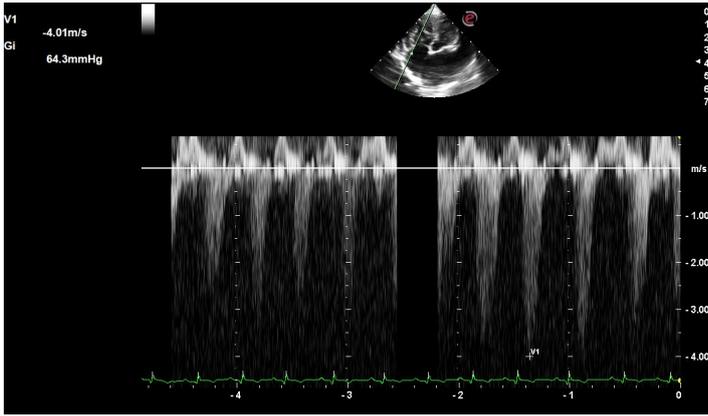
Continuous wave Doppler echocardiogram showing maximal tricuspid regurgitation velocity of 4.01 m/s, equivalent to systolic pulmonary artery pressure of 64.3 mmHg.
